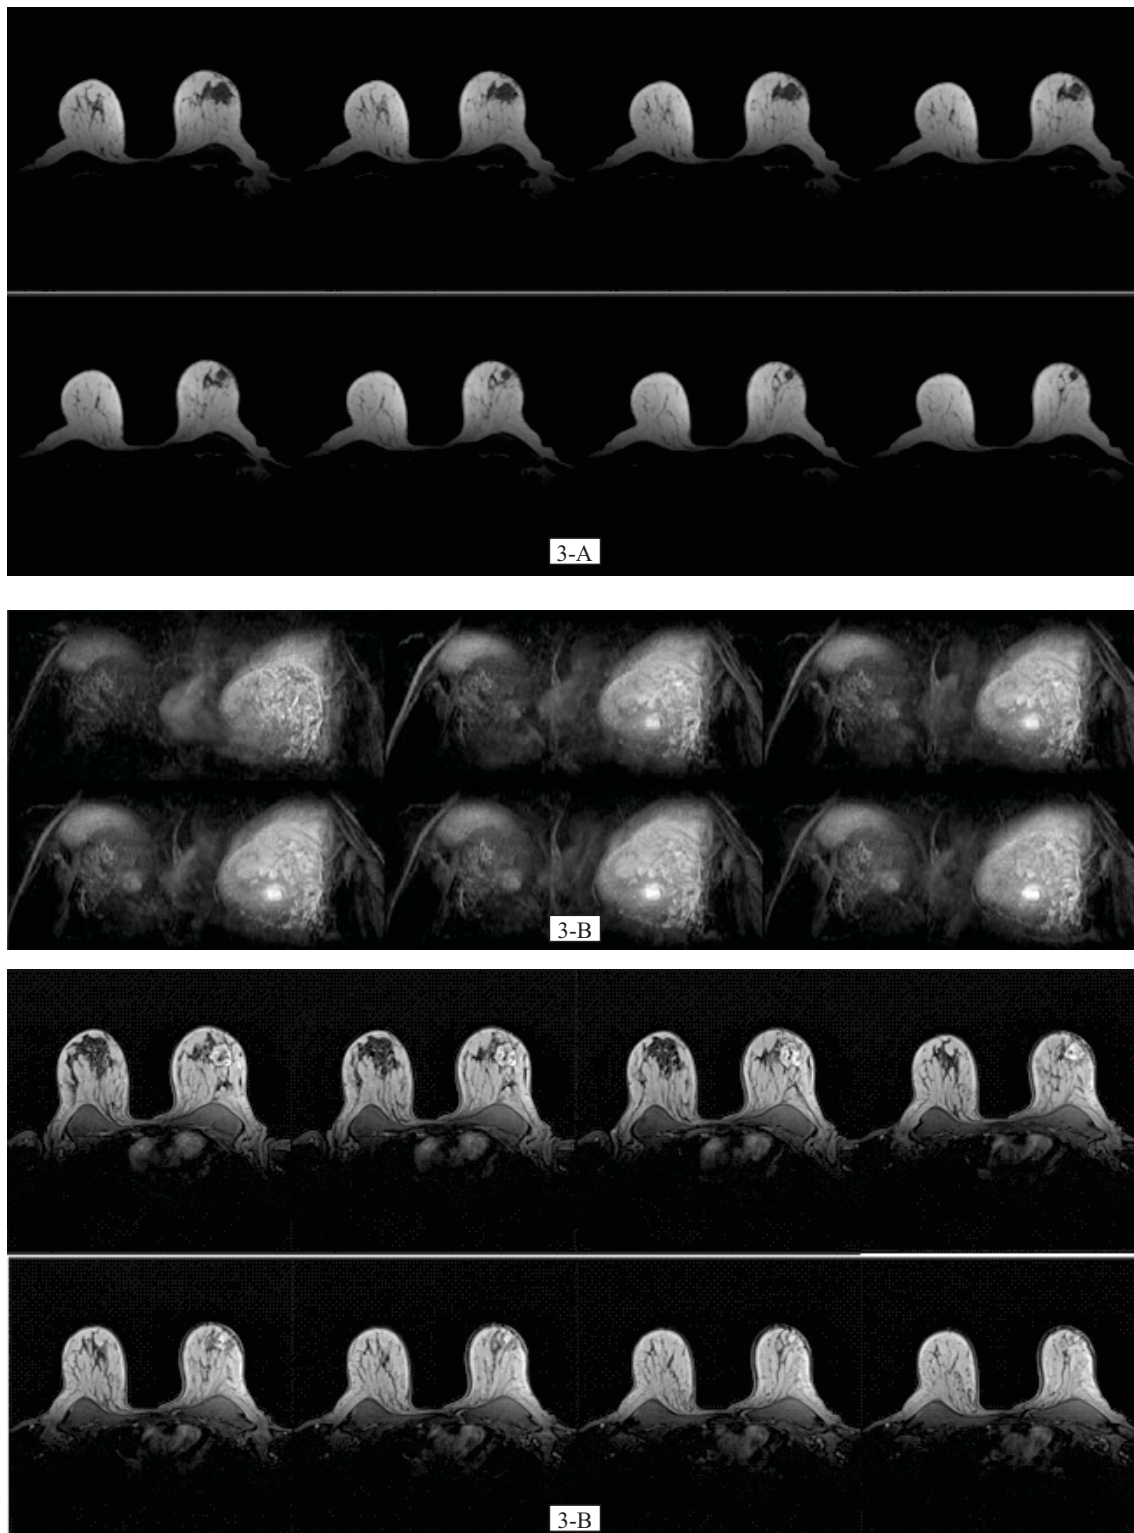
Dynamic MRI scan of both breasts without (3-A) & with (3-B) contrast showing enhanced masses in the upper outer quadrant of the left breast
